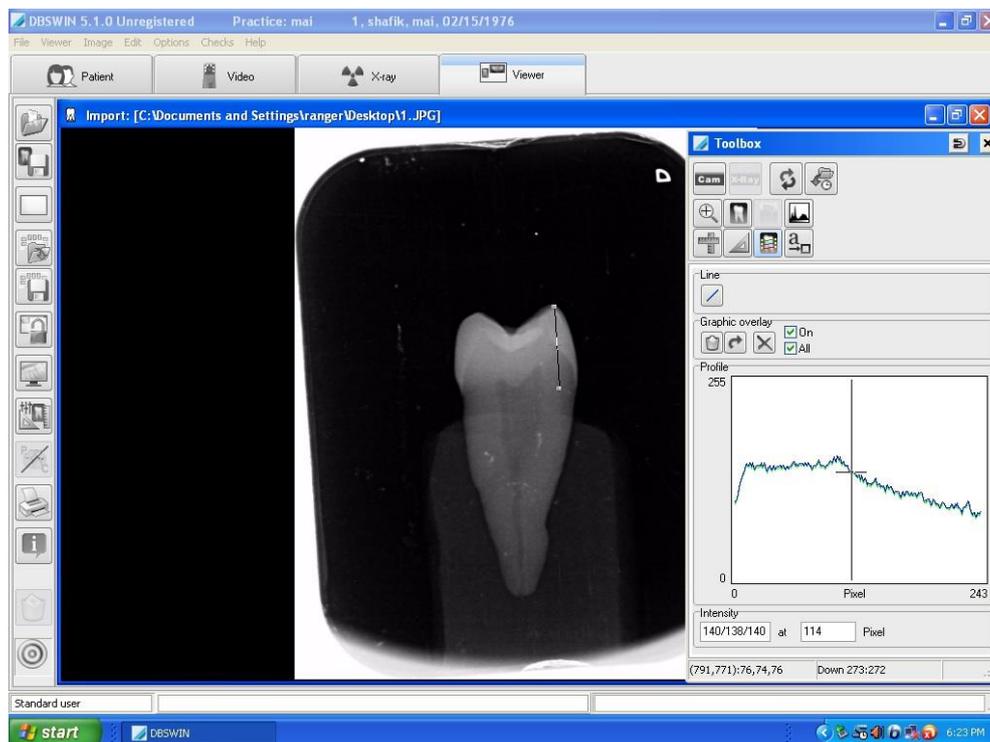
Densitometric radiographic measurement of enamel density using DBS-Win software on the Buccal surface of a premolar.
